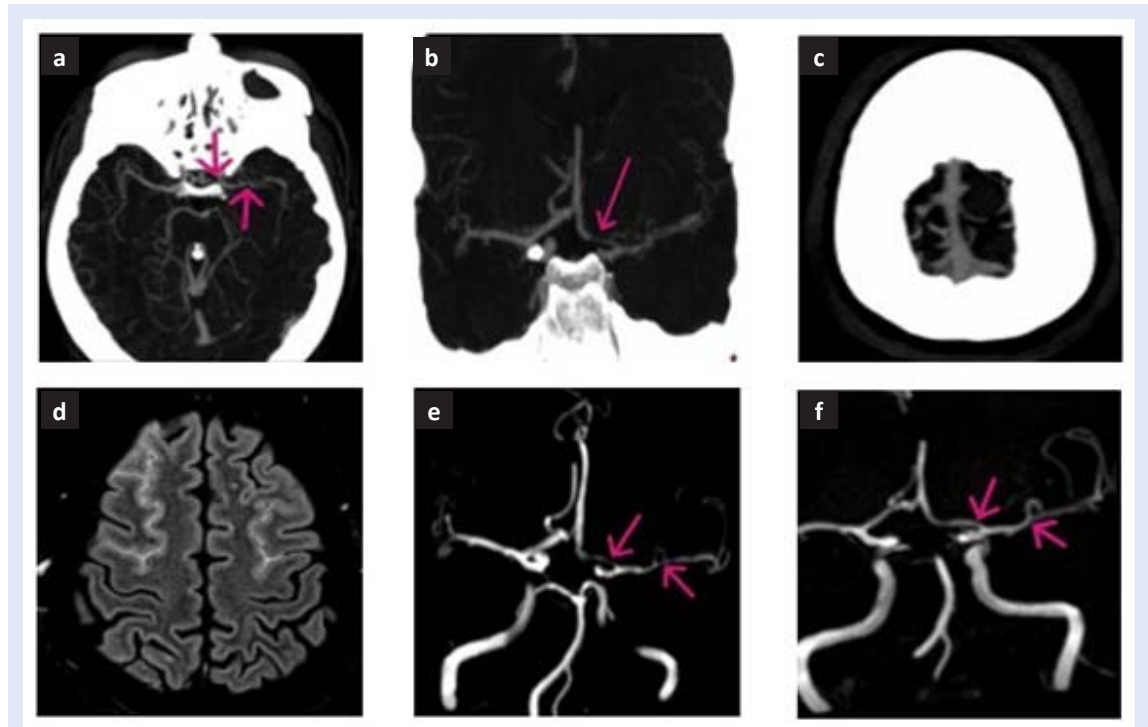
Reversible cerebral vasoconstriction syndrome (RCVS). CTA axial image showing vasospasm in the left ICA, M1 segment of MCA and A1 segment of ACA – arrows (a), CTA coronal image demonstrates the same vasospasm – arrows (b), CTA axial image depicting patent sagittal sinus (c), FLAIR MRI axial image showing bilateral convexity SAH (d), MRA of the circle of Willis with noticeable vasospasm – arrows indicate the most prominent changes (e), Follow-up MRA with proven resolution of vasospasm – arrows (f)
